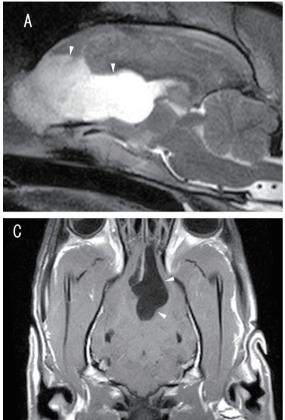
The first MRI. (A) Sagittal T2W image showing a large, hyperintense structure occupying the frontal lobe. (B) Transverse post-contrast T1W image at the level of the falx cerebri. The contrast-enhanced and slightly thickened falx was suggestive of a meningioma. (C) Dorsal post-contrast T1W image revealing an enhanced lesion adhering to the falx cerebri. There was no enhancement of the cystic wall. Uncleared sulci (narrowing subarachnoid space) of the cerebrum indicated increased ICP.
